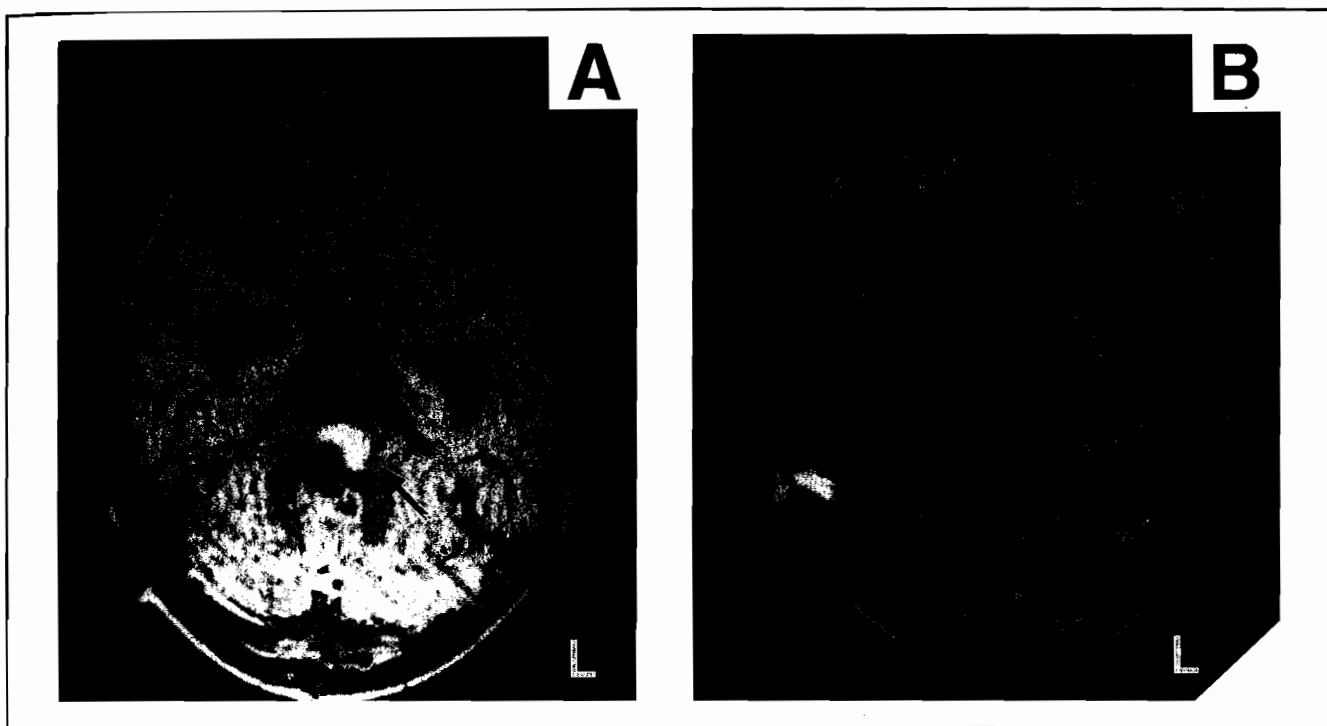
T_1 -weighted MRI of patient C5, 2 weeks (A) and 5 weeks (B) after resection of an ependymoma. Note hyperintense lesion (L > R) in pontine tegmentum in (A) (arrow), which is no longer present 3 weeks later (B).
